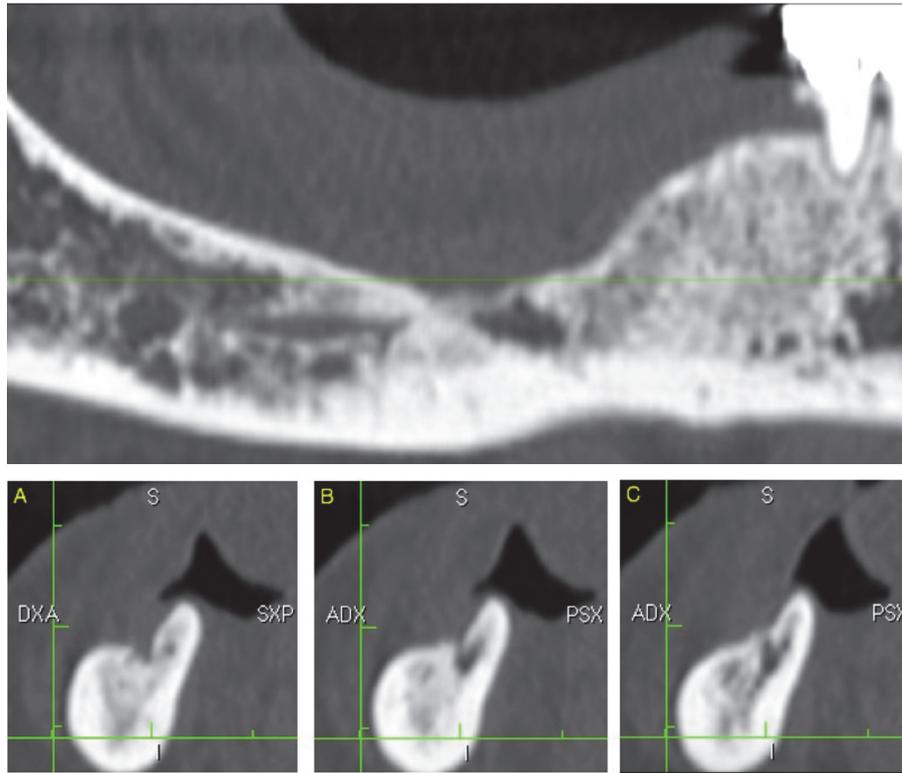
Radiologic outcome at 12 months' follow-up, CT scan slices.
